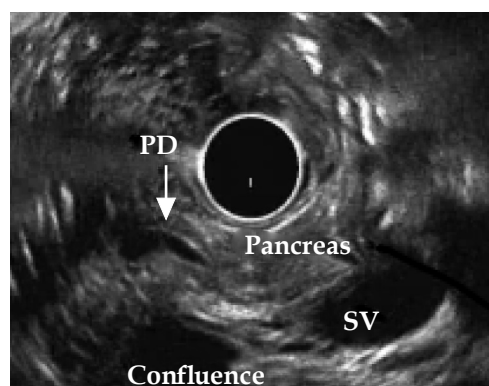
Radial EUS showing PD dipping downwards at genu towards the head in patient without pancreas divisum. EUS: endoscopic ultrasound; PD: pancreatic duct; SV: splenic vein.
